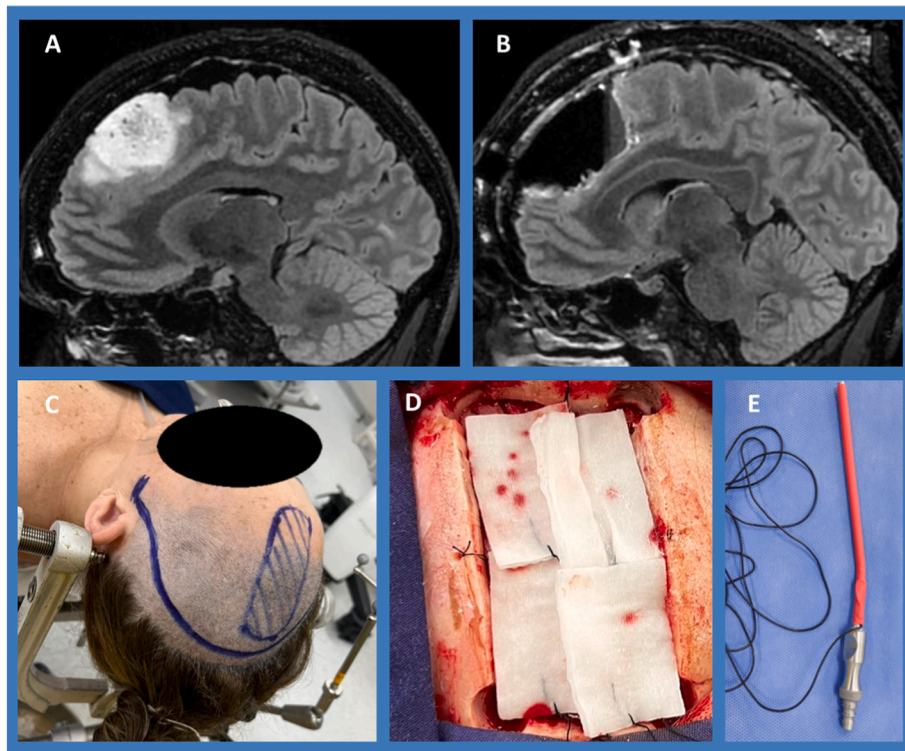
Case example of low grade glioma. A: Preoperative FLAIR sequence MRI showing parasagittal left frontal hyperintense lesion. B: Postoperative FLAIR sequence MRI showing complete resection. C: Position of the patient, planning of the incision and craniotomy. D: Placement of cotton pads with anesthetic on the dura mater. E: Aspiration and stimulation cannula with electrical insulation.
